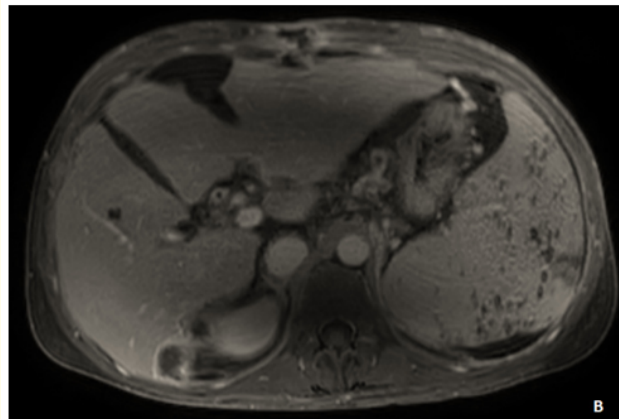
Axial MRI, T1WI with fat saturation section, after gadolinium administration at portal phase, shows multiple splenic foci of low signal intensity, related to Gamma Gandy bodies.
